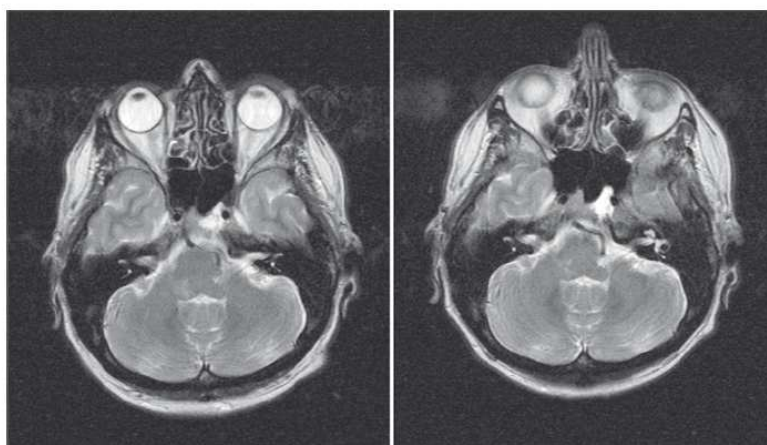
Magnetic resonance tomography imaging of a 48-year-old patient showing a marked hyperintensity in the right pons in T2-weighted images, indicating a right-sided rhombencephalitis (left picture). After 7 days of treatment, the extent of the inflammation was significantly smaller (right picture)
